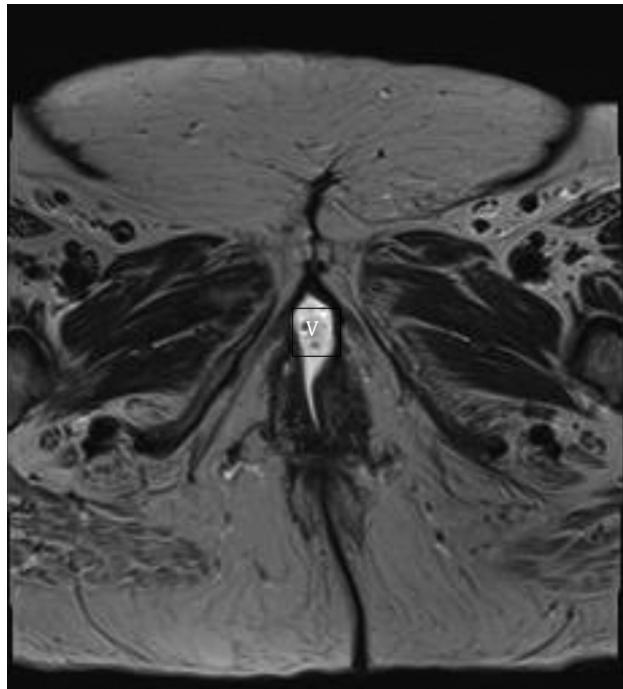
Axial T2-weighted image 30 months after surgery demonstrating further healing of the surgical site with no residual tumor seen. V: vaginal opening distended with gel.
